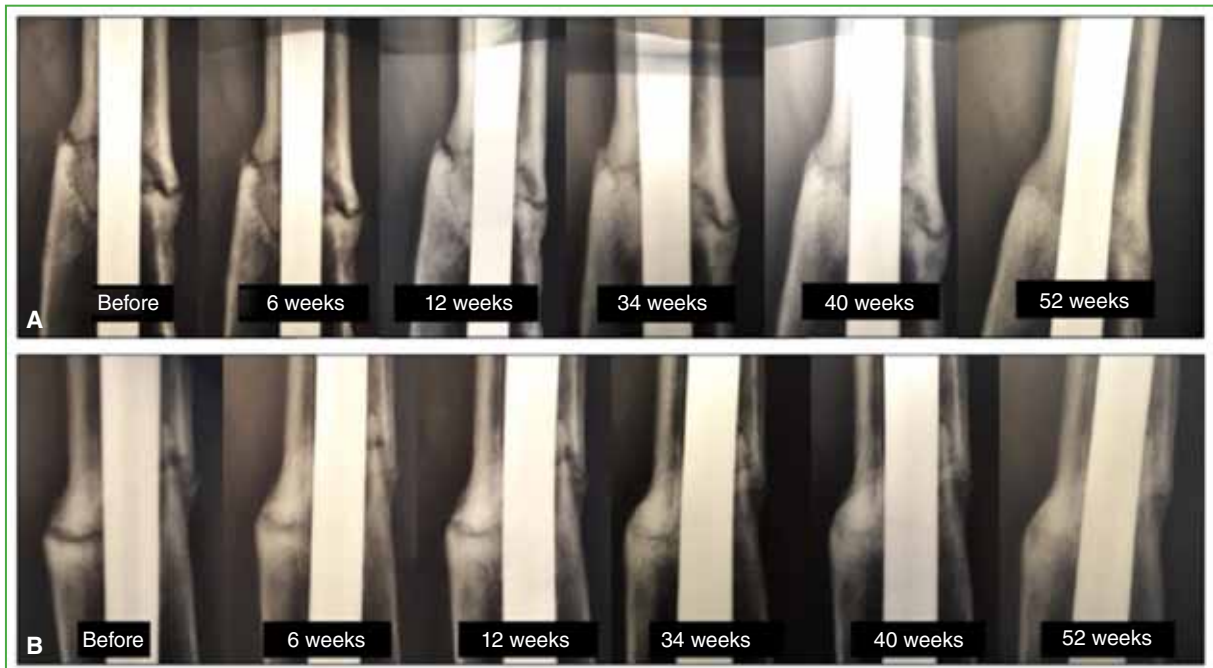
Progression of the consolidation process after applying a focused shockwave treatment plan in a patient with femoral pseudarthrosis of 20 months of evolution and two surgical procedures. The condition had progressed for ten months since the second surgery. A. Sequence of plain radiographs of the femur, AP view, with focus on the area of pseudarthrosis. B. Sequence of plain radiographs of the femur, lateral view, with focus on the area of pseudarthrosis.
